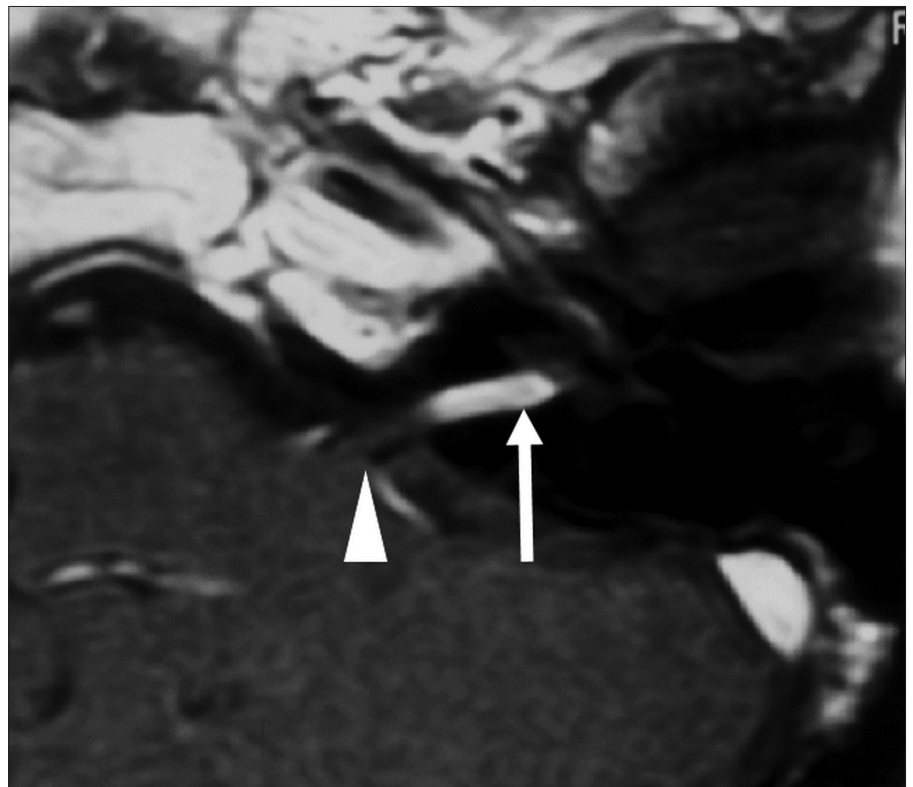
Contrast-enhanced axial T1-weighted image at the level of left IAC shows an intracanalicular enhancing mass (arrow). The CPC segment (arrowhead) and the labyrinthine segment (not shown) of the FN appear uninvolved. This mass, although proven to be an FNS on surgery, cannot be differentiated from a vestibular schwannoma on imaging.
